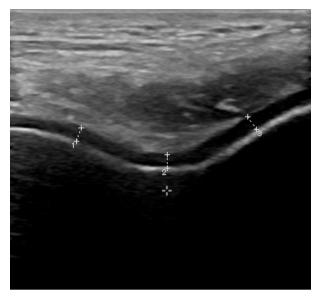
Cartilage thickness measurement zones on ultrasound.
